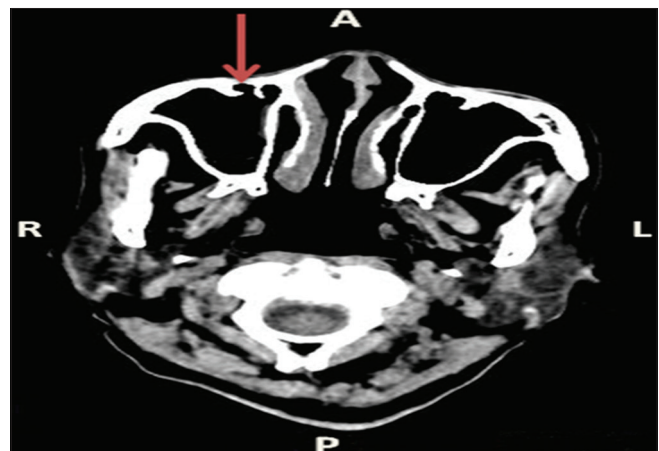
Axial computerized tomography (CT) slide of a 70-year-old female showing doubled septa (arrow) on the anterior wall of the right maxillary sinus. R = right side, L = left side, A = anterior, P = posterior
